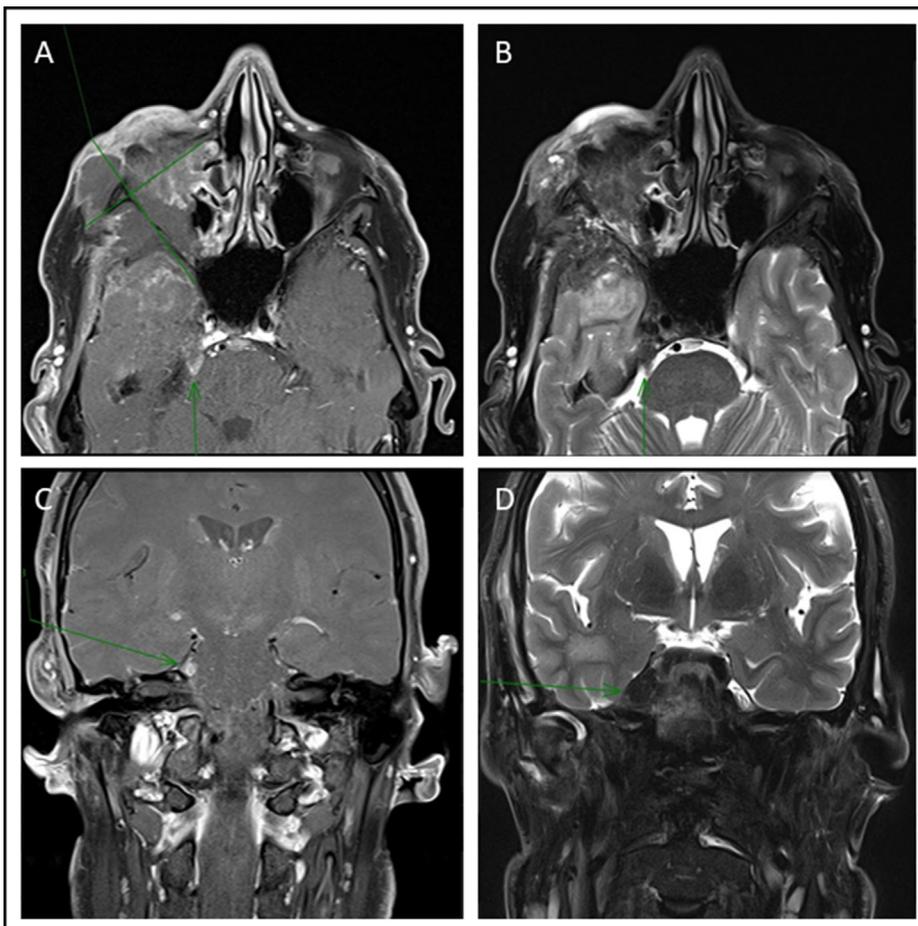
MR images demonstrating extensive cutaneous SCC extending to the middle cranial fossa with V3 involvement and enhancement to the nerve root exit at the right pons. (A) Axial post contrast T1 fat saturation image. (B) Axial T2 fat saturation image. (C) Coronal post contrast T1 fat saturation image. (D) Coronal T2 fat saturation image.
